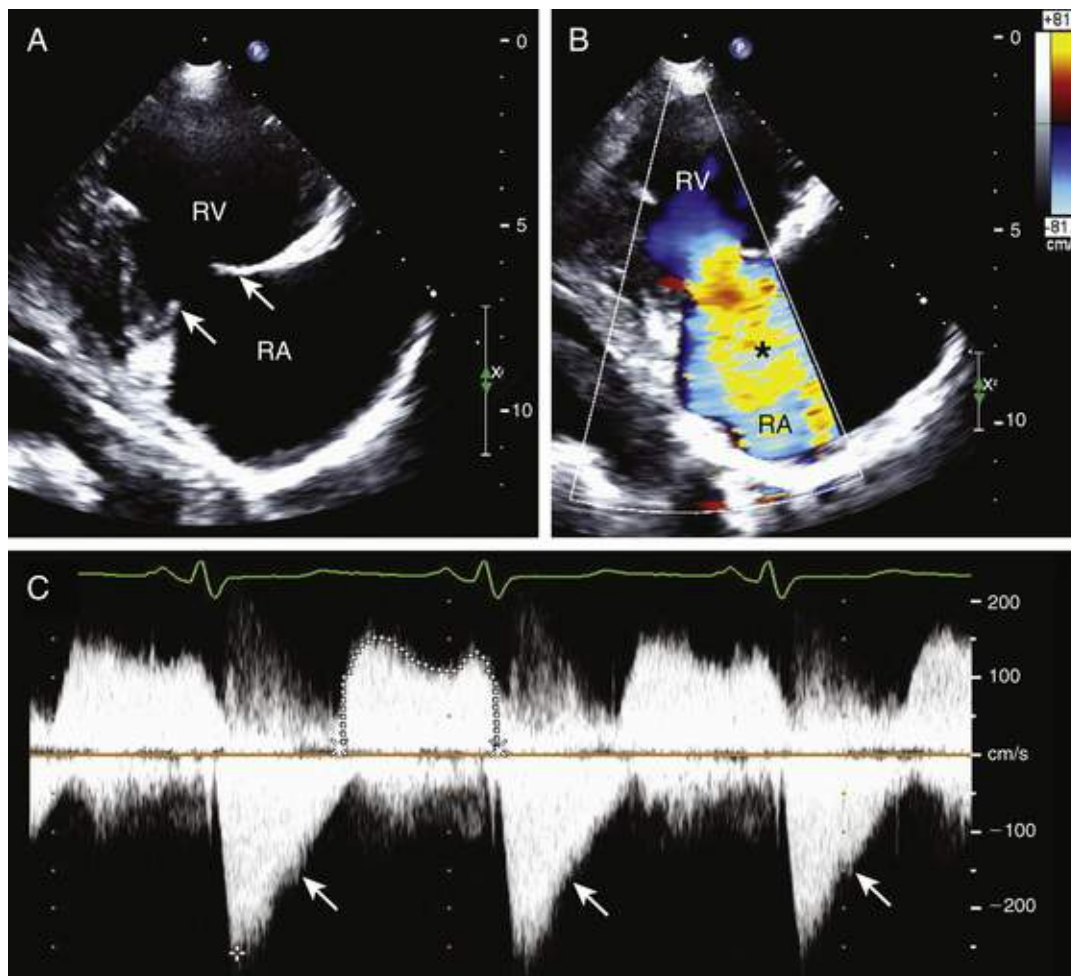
Transthoracic echocardiographic images of the tricuspid valve in a patient with carcinoid valvular heart disease. A, Two-dimensional parasternal long-axis image of the tricuspid valve inflow view in midsystole demonstrates a marked thickening and retraction of the tricuspid valve leaflets (*arrow*), resulting in failure of leaflet closure. B, Color Doppler imaging of the tricuspid valve in the parasternal long-axis tricuspid valve inflow view in midsystole demonstrates a broad regurgitant jet that occupies the entire right atrium, consistent with severe tricuspid valve regurgitation (*). RA, Right atrium; RV, right ventricle. C, Continuous-wave Doppler imaging across the tricuspid valve demonstrates a dense, systolic, dagger-shaped tricuspid regurgitant jet consistent with severe TR (*arrow*). Less severe forms of TR are typically associated with parabolic-shaped regurgitant jets. (From Luis SA, Pellikka PA. Carcinoid heart disease: diagnosis and management. *Best Pract Res Clin Endocrinol Metab* 2016;30:149.)
